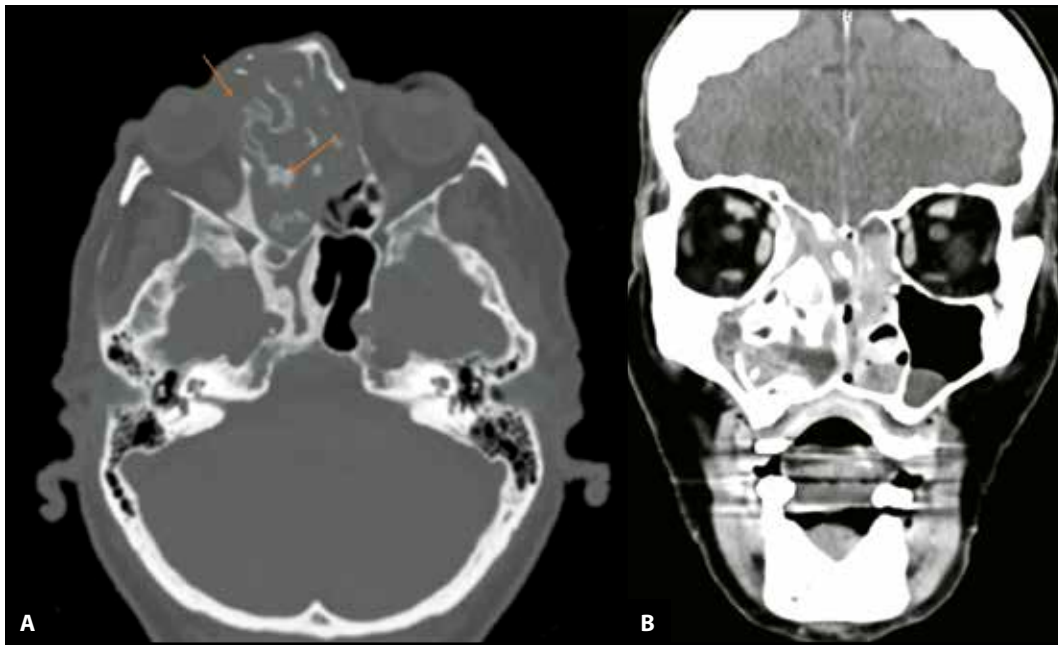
Cranio-facial CT scan (axial (A) and coronal (B) sections) showing areas of metaplastic/heterotopic ossification, lamina papyracea thinning and orbital roof remodelling (orange arrows).
